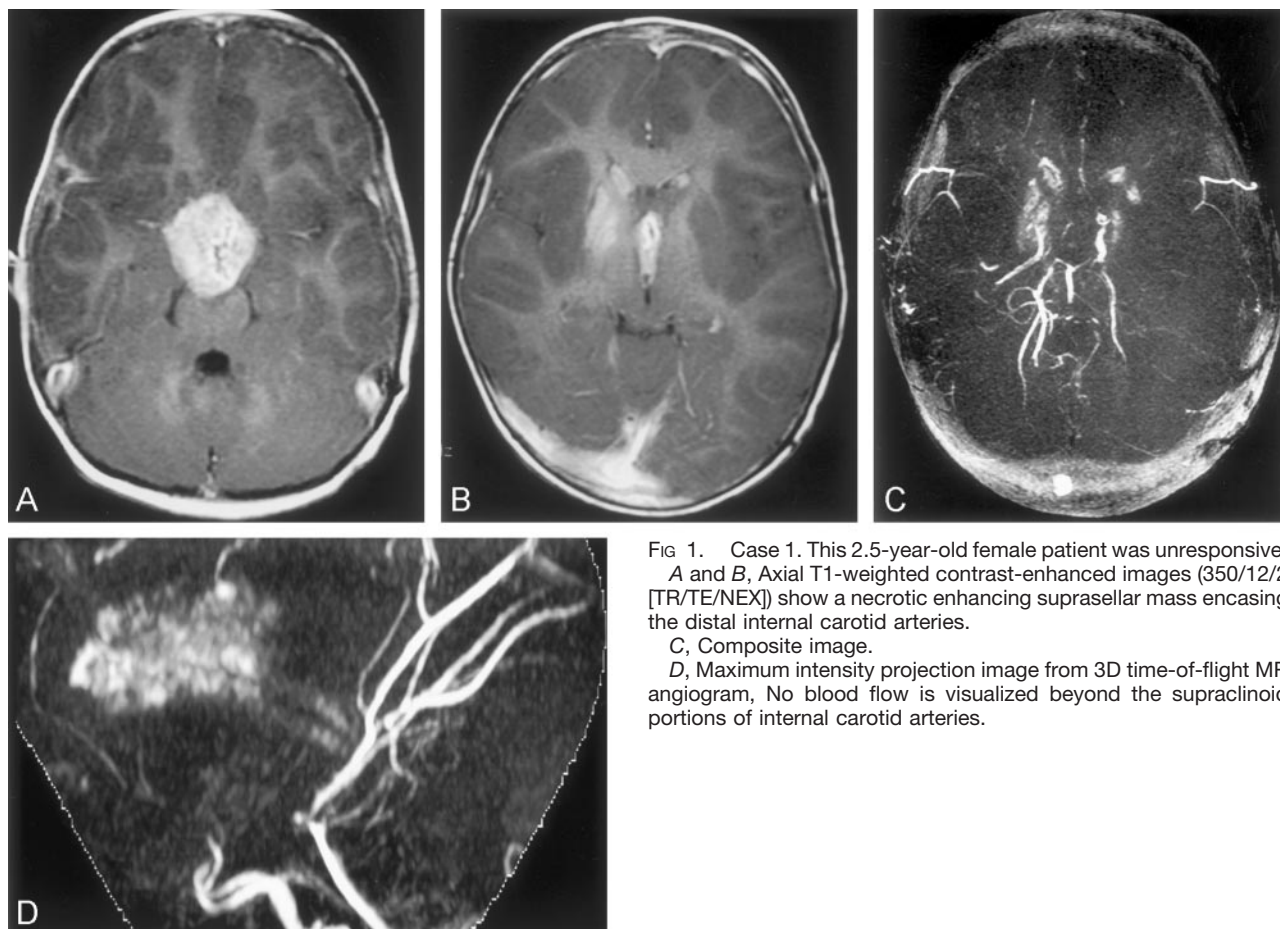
Case 1. This 2.5-year-old female patient was unresponsive. A and B, Axial T1-weighted contrast-enhanced images (350/12/2 [TR/TE/NEX]) show a necrotic enhancing suprasellar mass encasing the distal internal carotid arteries.
